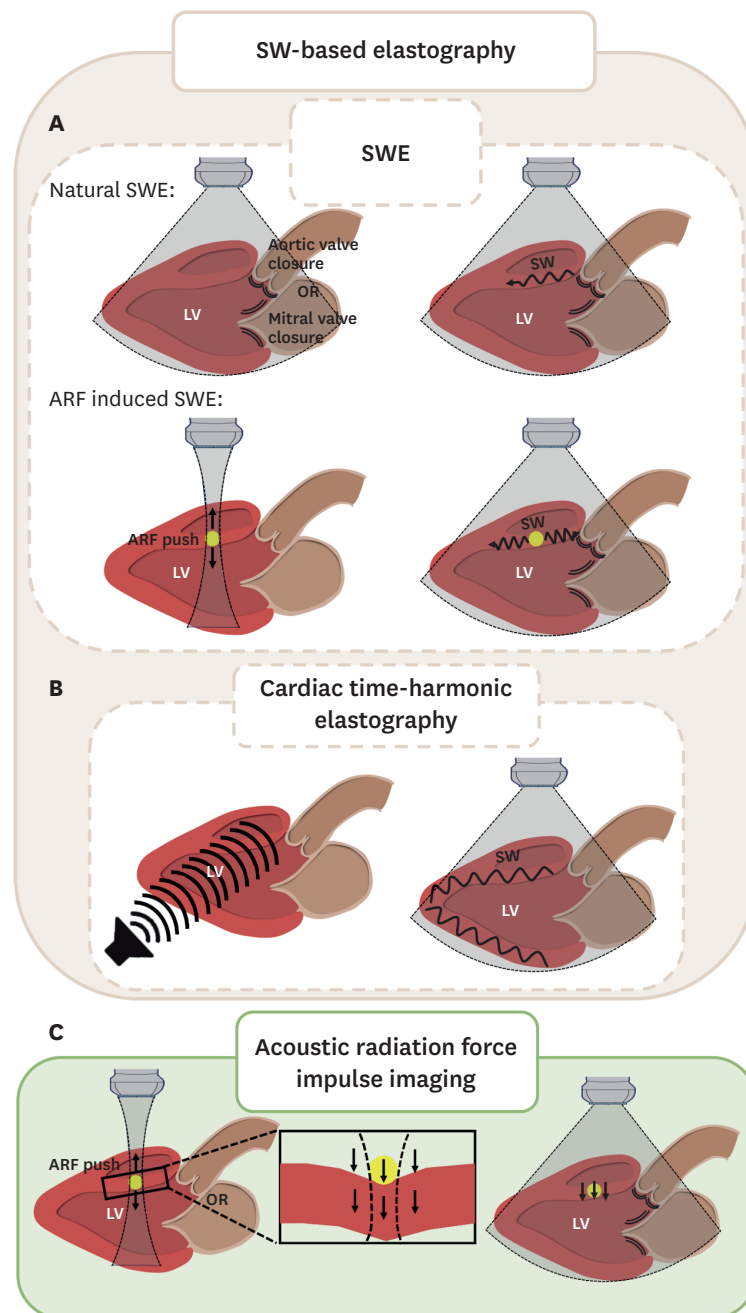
Overview of ultrasound-based techniques to determine myocardial stiffness. (A) SWE. The 2 most used techniques within SWE are shown: natural SWE, where SWs that arise from closure of the valves are tracked and ARF induced SWE, where SW are induced by sending a focused ultrasound push towards the septum. (B) Cardiac time-harmonic elastography. SWs are induced in the whole imaging window by sending low-frequency vibrations with an external vibrator. (C) Acoustic radiation force impulse imaging: This techniques looks directly at tissue displacement induced by an acoustic radiation force impulse to determine tissue stiffness. It is based on the principle that the magnitude of the ARF-displacement is inversely related to tissue stiffness. ARF = acoustic radiation force; LV = left ventricle; SW = shear wave; SWE = shear wave elastography.
